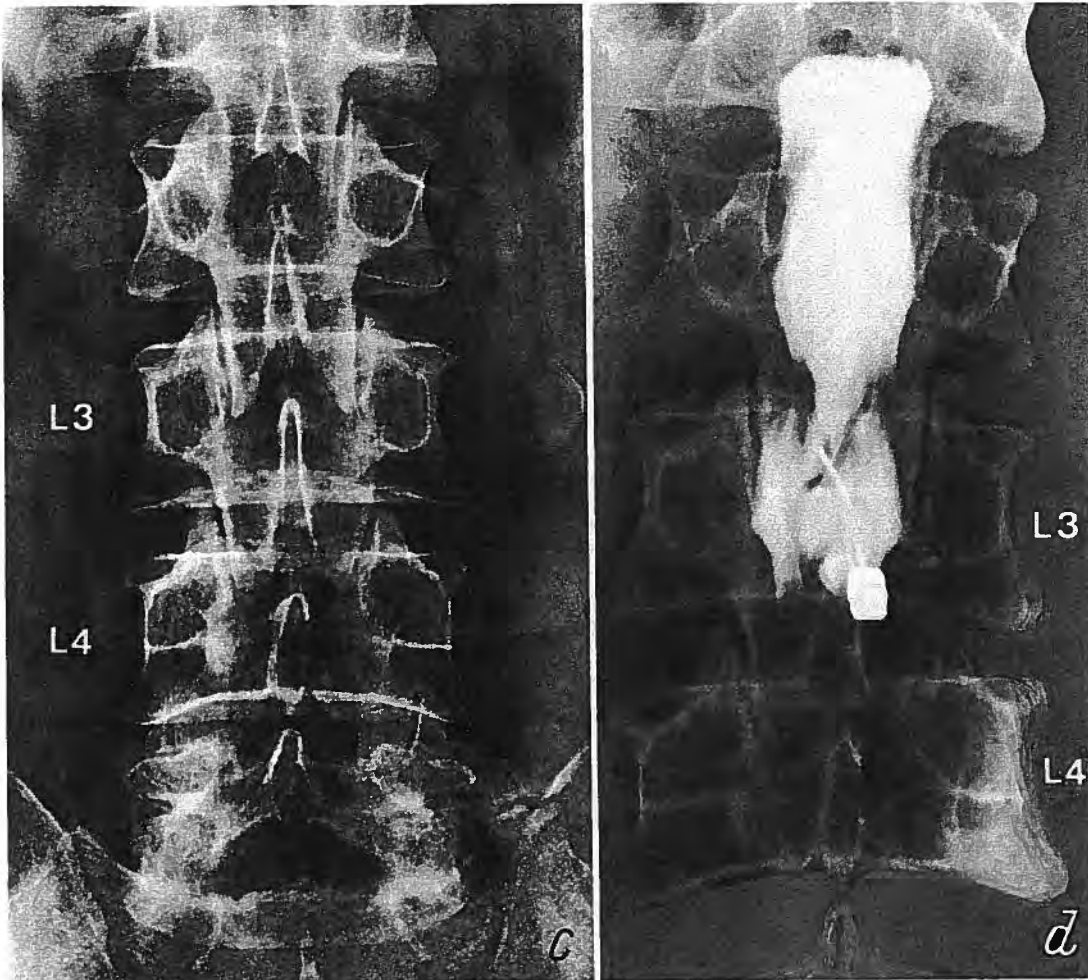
a An antero-posterior radiograph of the lumbar spine of a woman aged 55 years. Note the scoliosis with its apex at the L3/4 level. *This is one of the rare causes of degenerative scoliosis in middle-aged women due to acute vertebral end-plate necrosis.* The deformities resulting from this lesion are often complex with both kyphotic and scoliotic components contributing to the overall deformity. b An antero-posterior radiograph of the myelogram in this case showing a complete block at the L3/4 level with stenotic changes at L2/3 above
